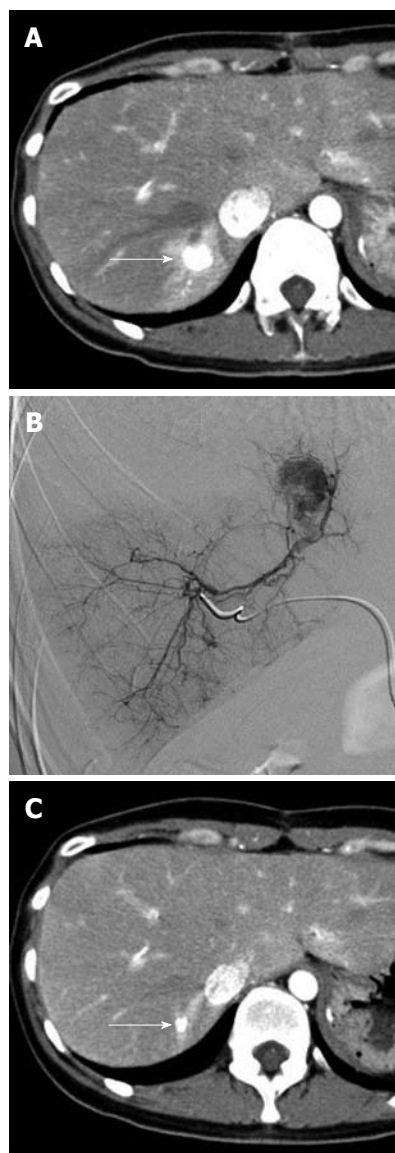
Images obtained in the case of a 35-year-old woman with a solitary neuroendocrine metastasis of the liver. A: Arterial phase image of contrast-enhanced computed tomography (CT) before intervention shows a hyperdense metastatic tumor in the right posterior segment surrounded by arterioportal shunting (arrow); B: Selective angiogram from the right posterior arterial segment delineates a single hypervascular metastatic tumor with arterioportal shunting; C: Arterial phase image of contrast-enhanced CT at 3 mo after chemoembolization with miriplatin-iodized oil suspension demonstrates a significant reduction in tumor size with compact accumulation of iodized oil accompanied by surrounding arterioportal shunting (arrow).
